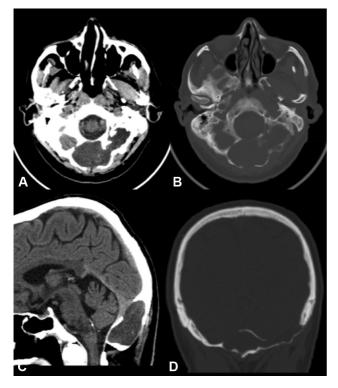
Head computed tomography scan showing an occipital osteolytic hypodense intradiploic expansive lesion. Note the widening of the diploic space with smooth bone remodeling, thinning of the inner and outer tables, and associated bony defects.
